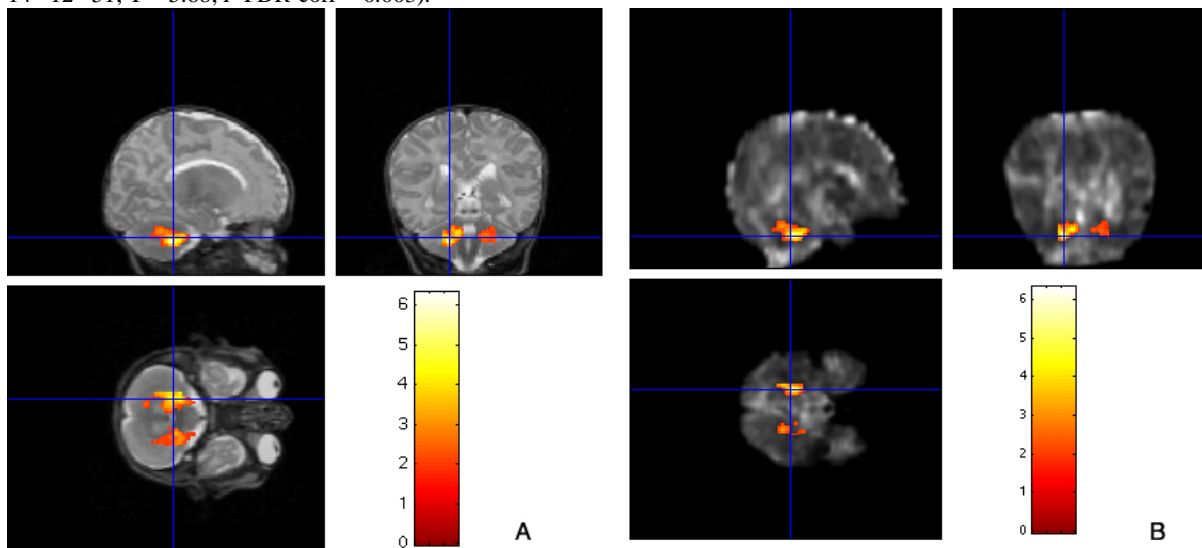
Visualisation of the regions of significant reduction in FA values in IUGR infants. A : overlaid on T2-weighted image B: overlaid on FA map
